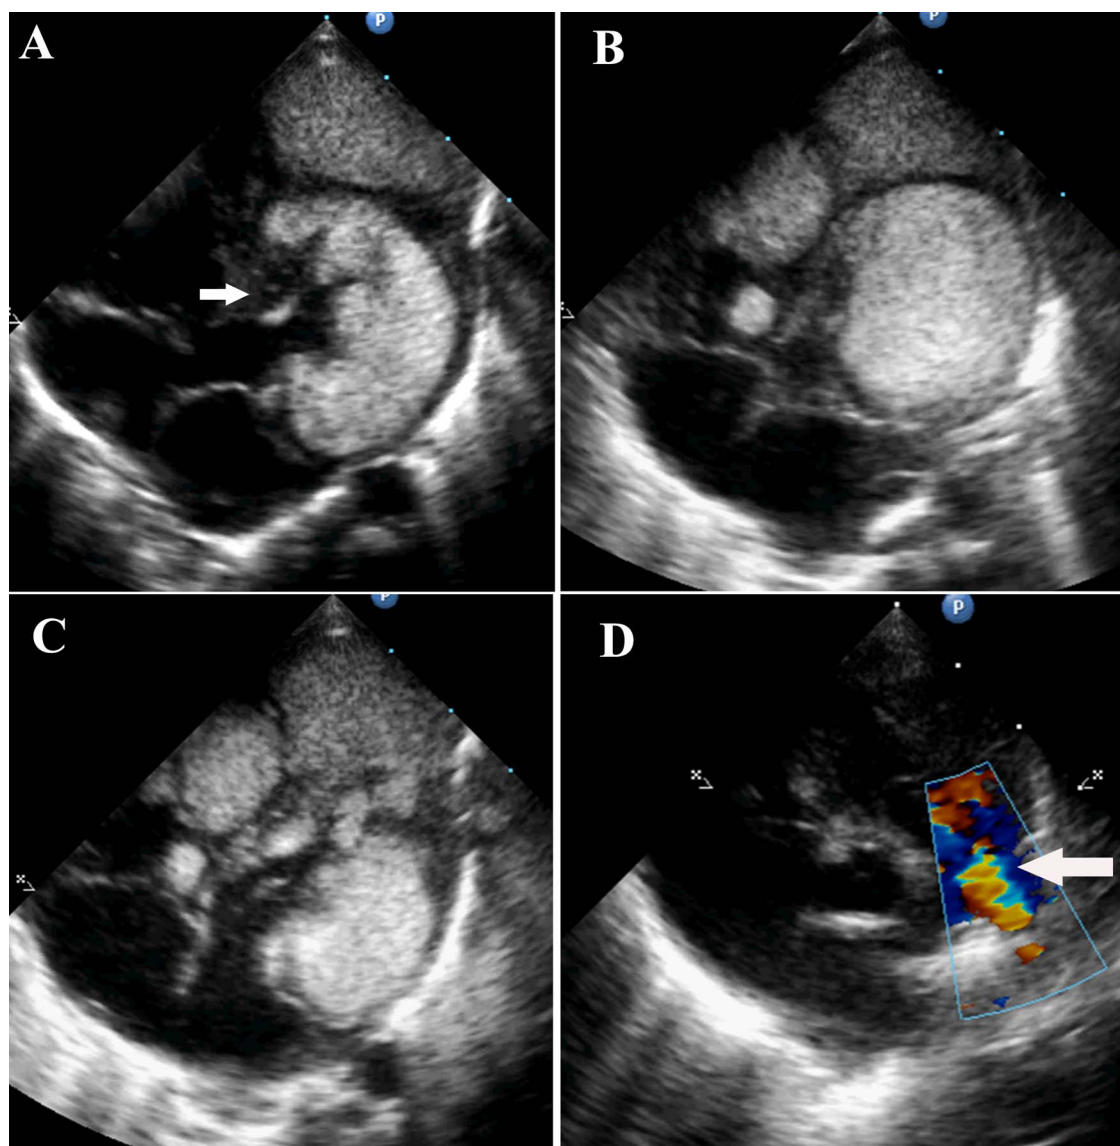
Transthoracic echocardiogram. (A) Apical four-chamber view, showing tumour mimicking appearance of foetus (arrow). (B) Apical four-chamber view: large tumours involving both ventricles and apex. (C) Apical four-chamber view: multiple tumours involving both cardiac chambers and interventricular septum. (D) Parasternal short-axis view showing continuous flow of patent ductus arteriosus (arrow).
